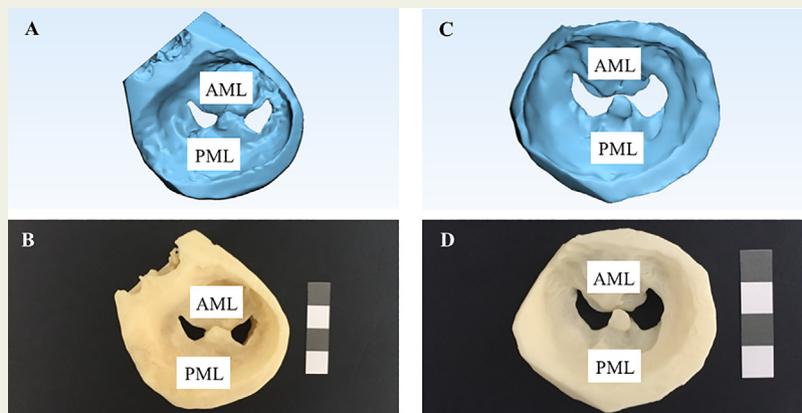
Virtual and 3D printed MV models for patient 1 with MV prolapse. Cardiac CT and 3D echocardiography imaging data was used to produce virtual 3D models (A and C respectively), which were 3D printed using fused deposition modelling (B and D respectively) to compare 3D printed models produced from different imaging modalities. Abbreviations: 3D, three dimensional; MV, mitral valve; AML, anterior mitral leaflet; PML, posterior mitral leaflet. [Note: calibration inset, 10 mm x 10 mm squares].
